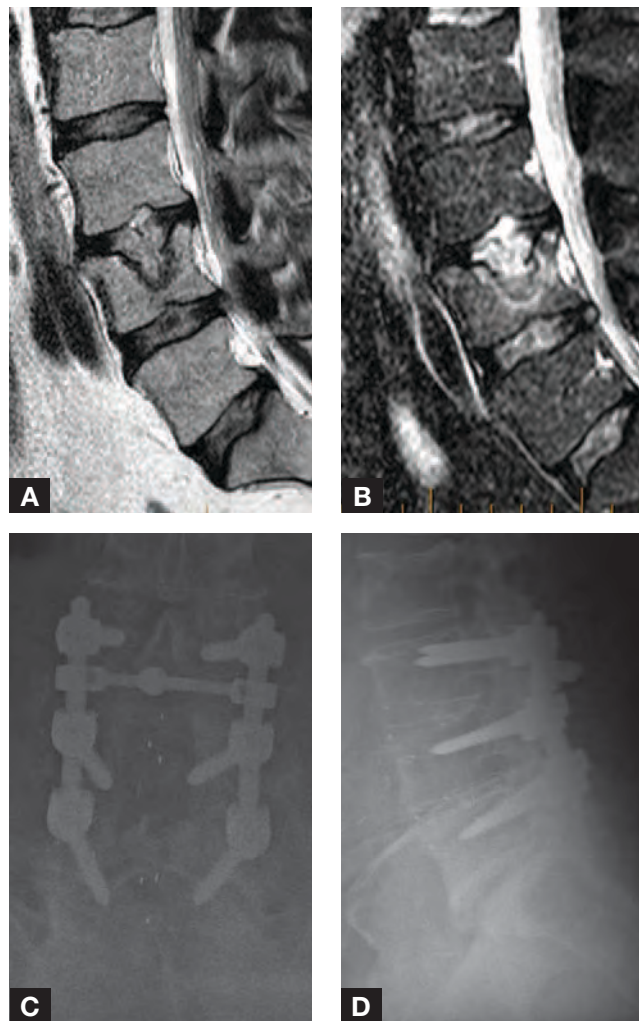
(A) Sagittal T2 and (B) STIR MRI shows disc material with L4 vertebral body and surrounding edematous changes. (C) Follow-up postoperative anteroposterior and (D) lateral radiograph.
